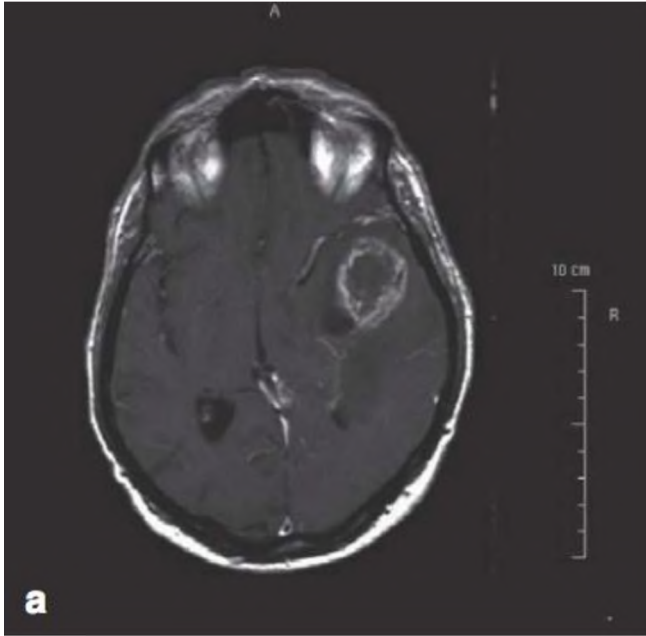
Magnetic Resonance Image of Glioblastoma in the Cerebral Hemisphere.¹
